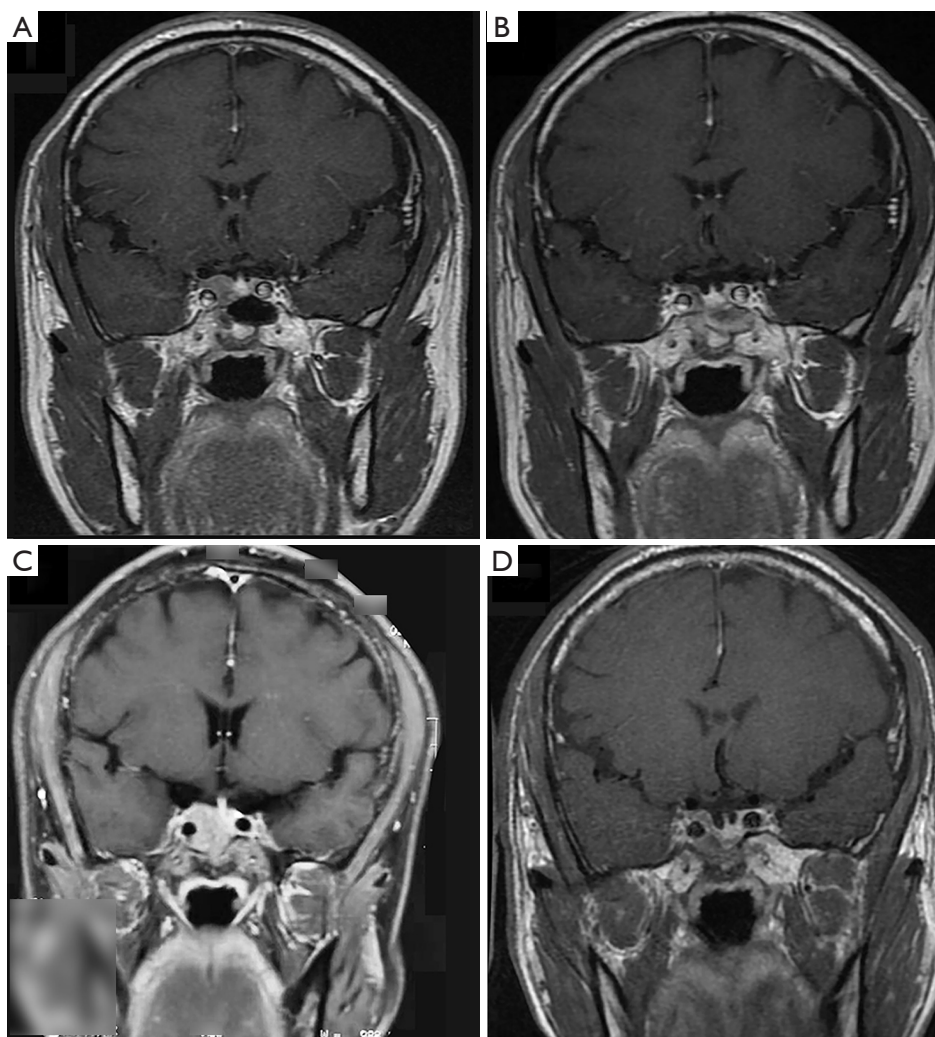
Images in different stages. (A) Preoperative MRI image in April 2017: there is an 11 mm × 11 mm × 12 mm macroadenoma surrounding the internal carotid artery. (B) MRI image 3 months postoperatively showing some remnant tumor tissue (6 mm × 5 mm × 6 mm) in irregular shape surrounding the internal carotid artery. (C) Preoperative MRI image in 2022 showing tumor regrowth (17 mm × 17 mm × 19 mm). (D) MRI image 3 months after the second surgery showing some remnant tumor tissue (8 mm × 10 mm × 8 mm) still existing. MRI, magnetic resonance imaging.
